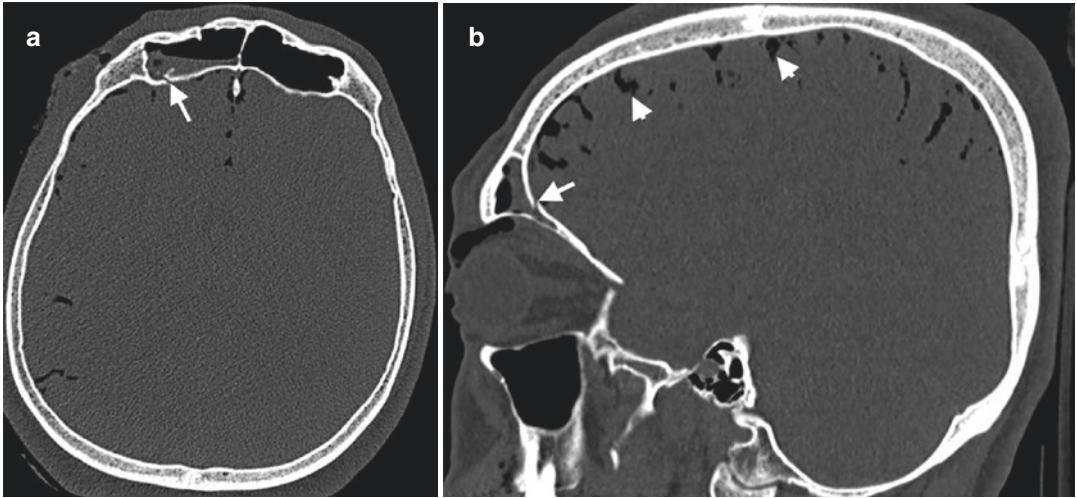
Posterior frontal sinus wall fracture. Axial (a) and sagittal (b) CT images demonstrate depressed fracture of posterior wall of the frontal sinus (arrows) and resultant pneumocephalus (arrowheads)
